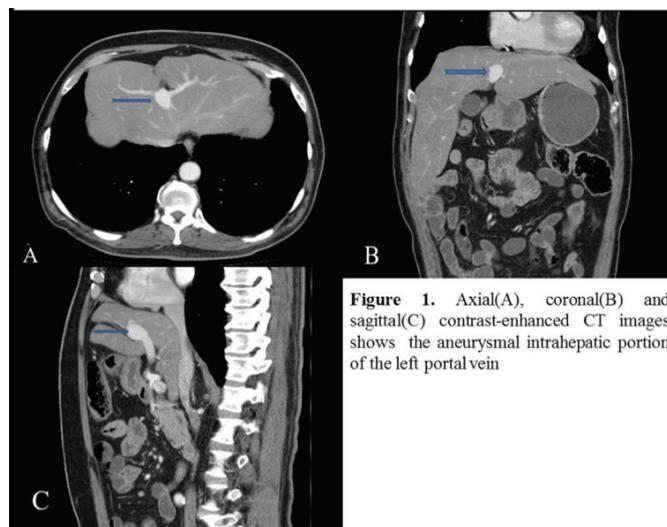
Axial(A), coronal(B) and sagittal(C) contrast-enhanced CT images shows the aneurysmal intrahepatic portion of the left portal vein
